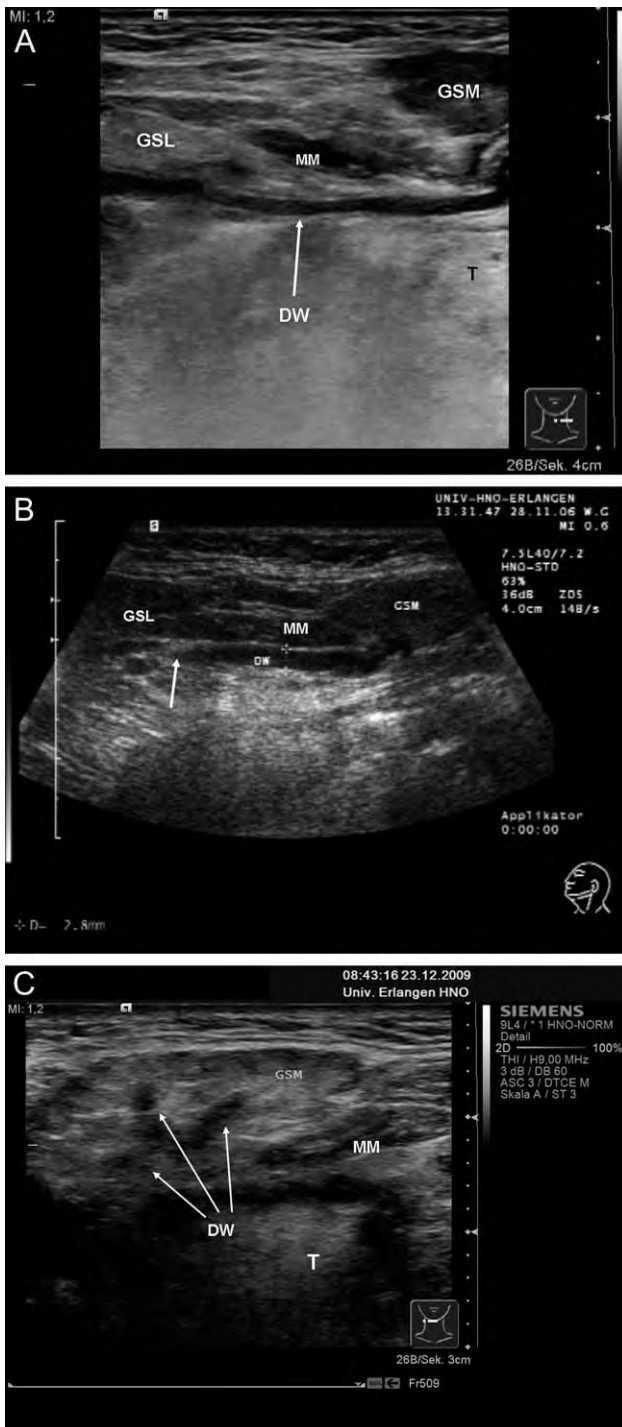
Ultrasound findings in stenoses of the submandibular duct (Wharton's duct) in various locations. (A) Stenosis in the distal area of the duct; the whole length of the duct is congested (white arrow). (B) Stenosis in the middle third of the duct, showing the ductal system with proximal congestion and ductal discontinuity (white arrow). (C) A central posthilar stenosis. The ductal system is congested up to the intraparenchymal area (white arrows), and it is not visible distal to the hilar area. DW = Wharton's duct; GSL = sublingual gland; GSM = submandibular gland; MM = mylohyoid muscle; T = tongue.
